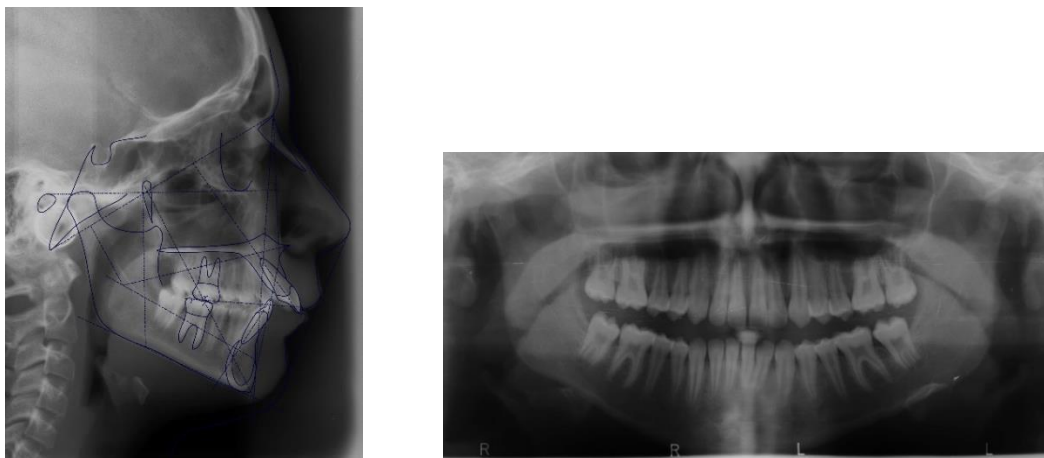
Teleradiographic and orthopantomography records of the patient pre-treatment.
